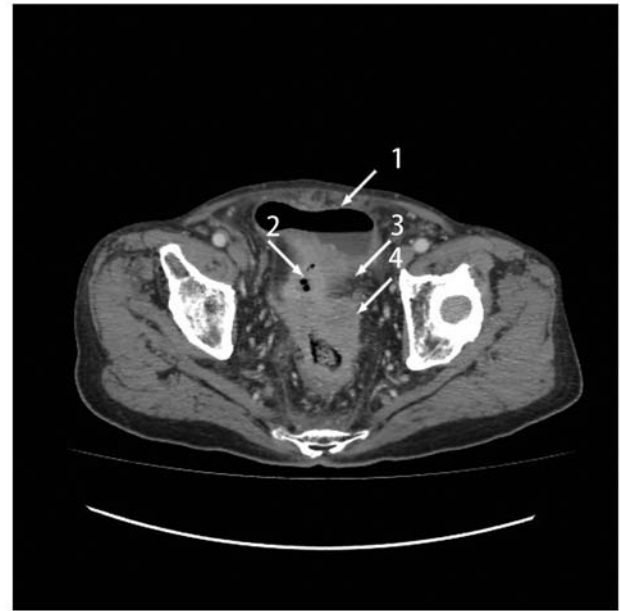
Computed tomography showing air in the bladder (arrow 1), thickening in the sigmoid colon, rectum and bladder wall (arrows 3 and 4), and a fistula between the colon and bladder (arrow 2).
